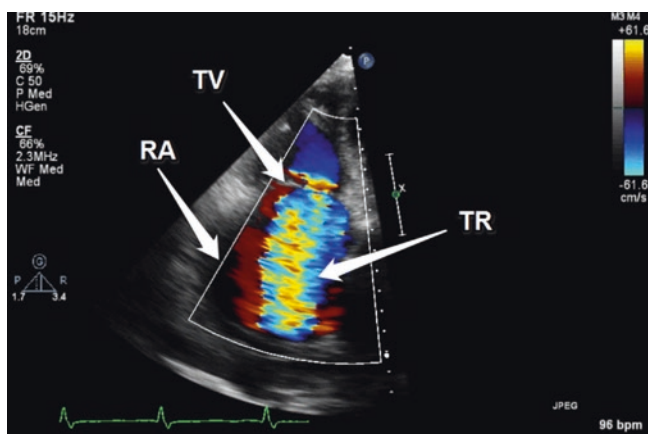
This image shows the color Doppler jet from severe tricuspid regurgitation (TR) going across the tricuspid valve (TV) into the right atrium (RA)
